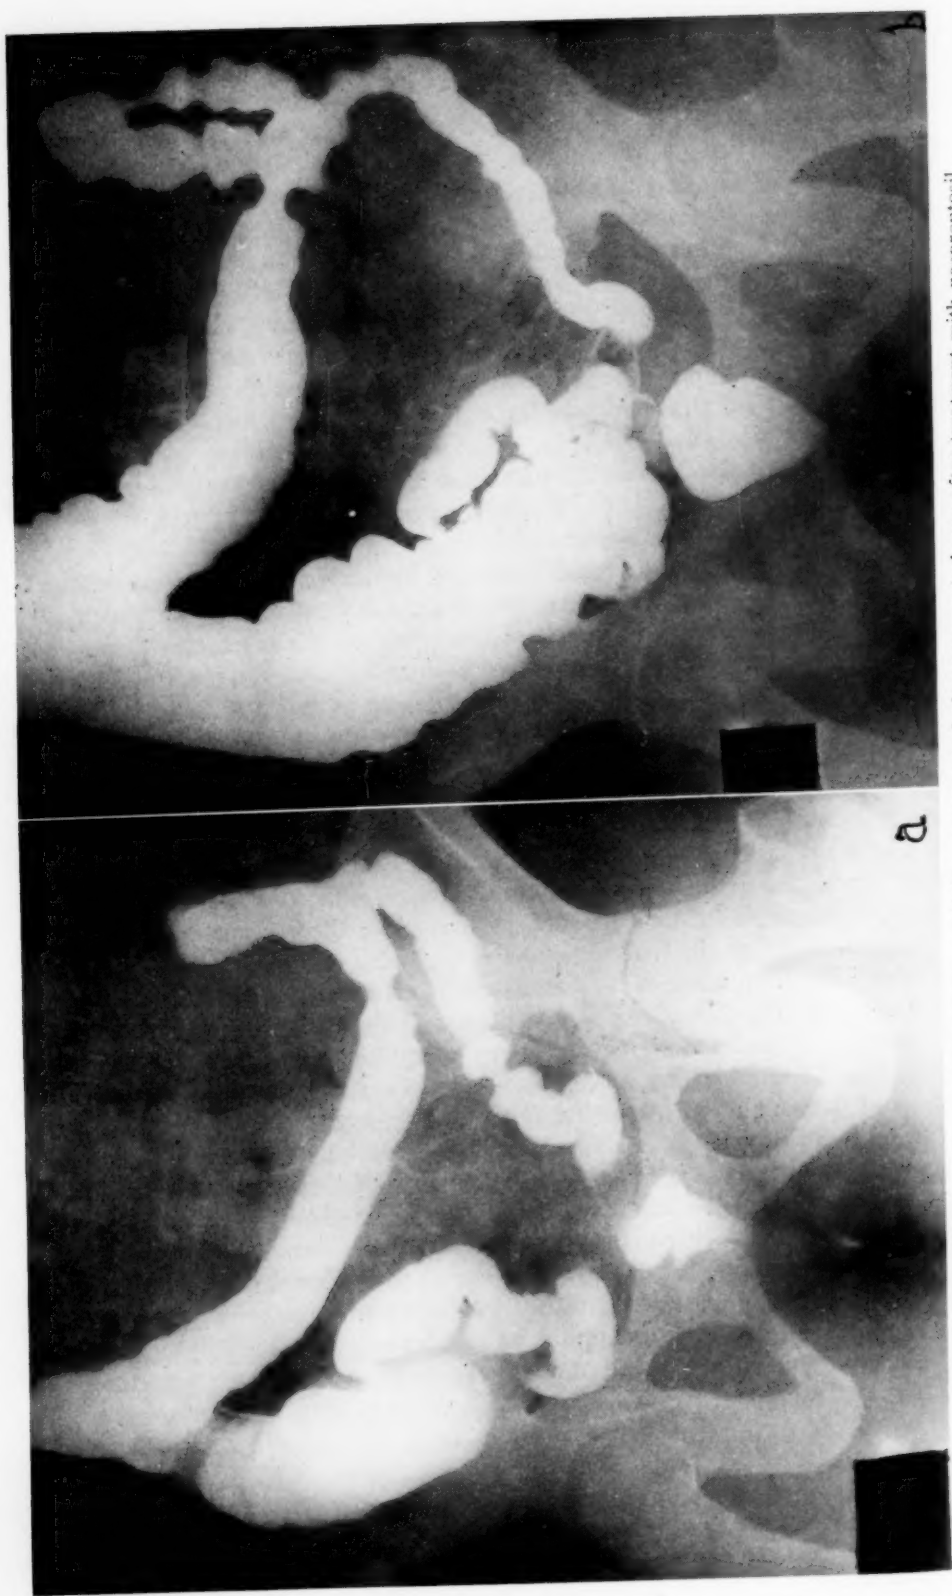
Roentgenograms of the barium enema. *a*, Before treatment; *b*, improvement shown after treatment with neoprontosil.
